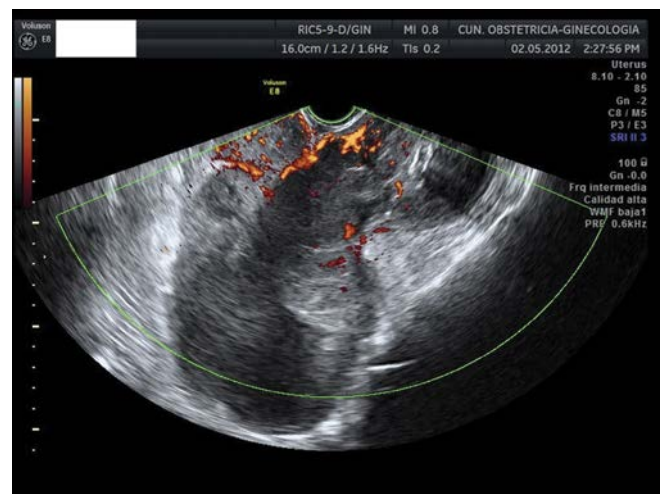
Transvaginal ultrasound in a case of endometrial stromal sarcoma. The uterus is hardly recognizable.
